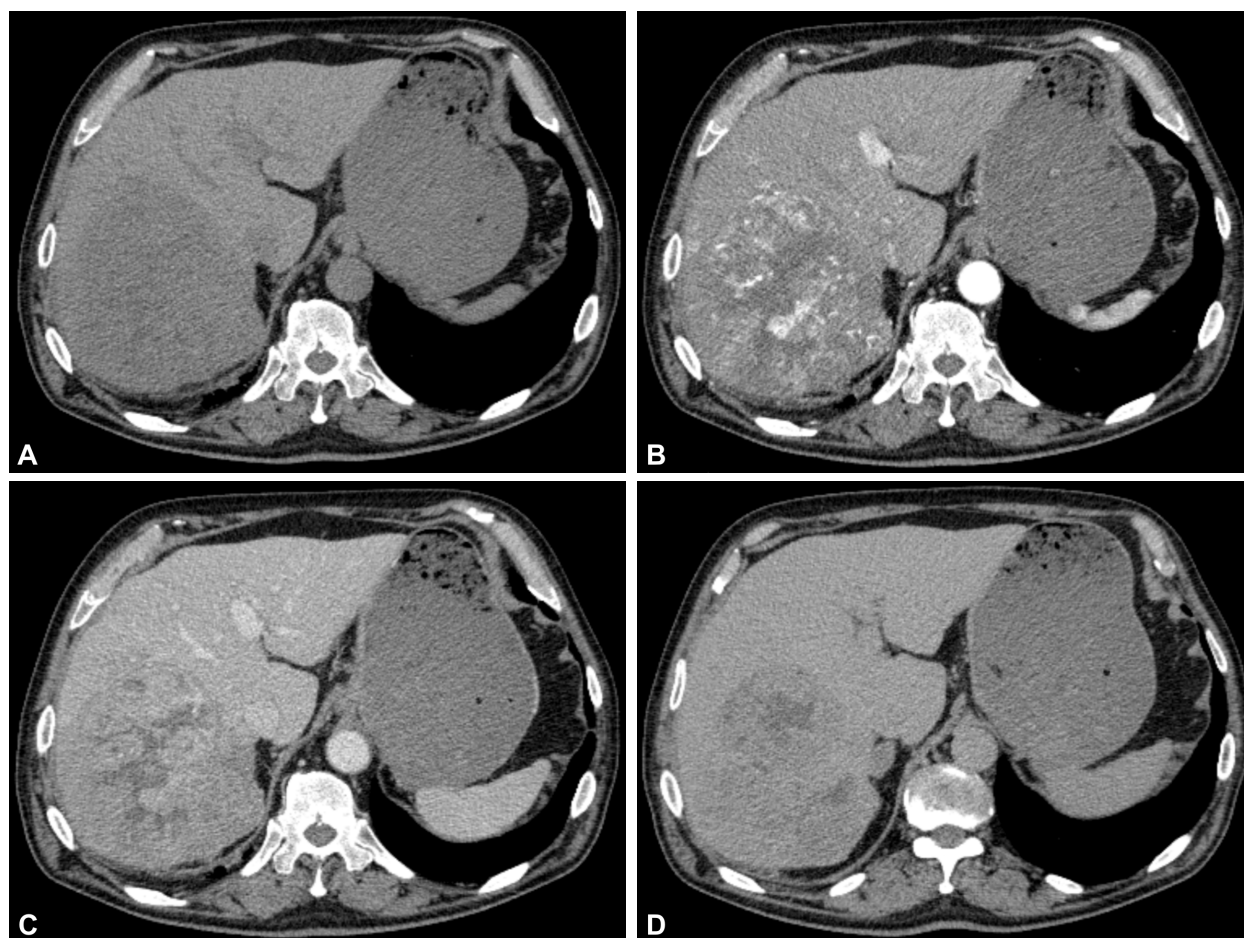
CT scan of a large primary liver tumor with dynamic representation of the parenchyma during contrast administration: (A) Native aspect; (B) Arterial phase; (C) Venous phase; (D) Late phase. CT: Computed tomography.
